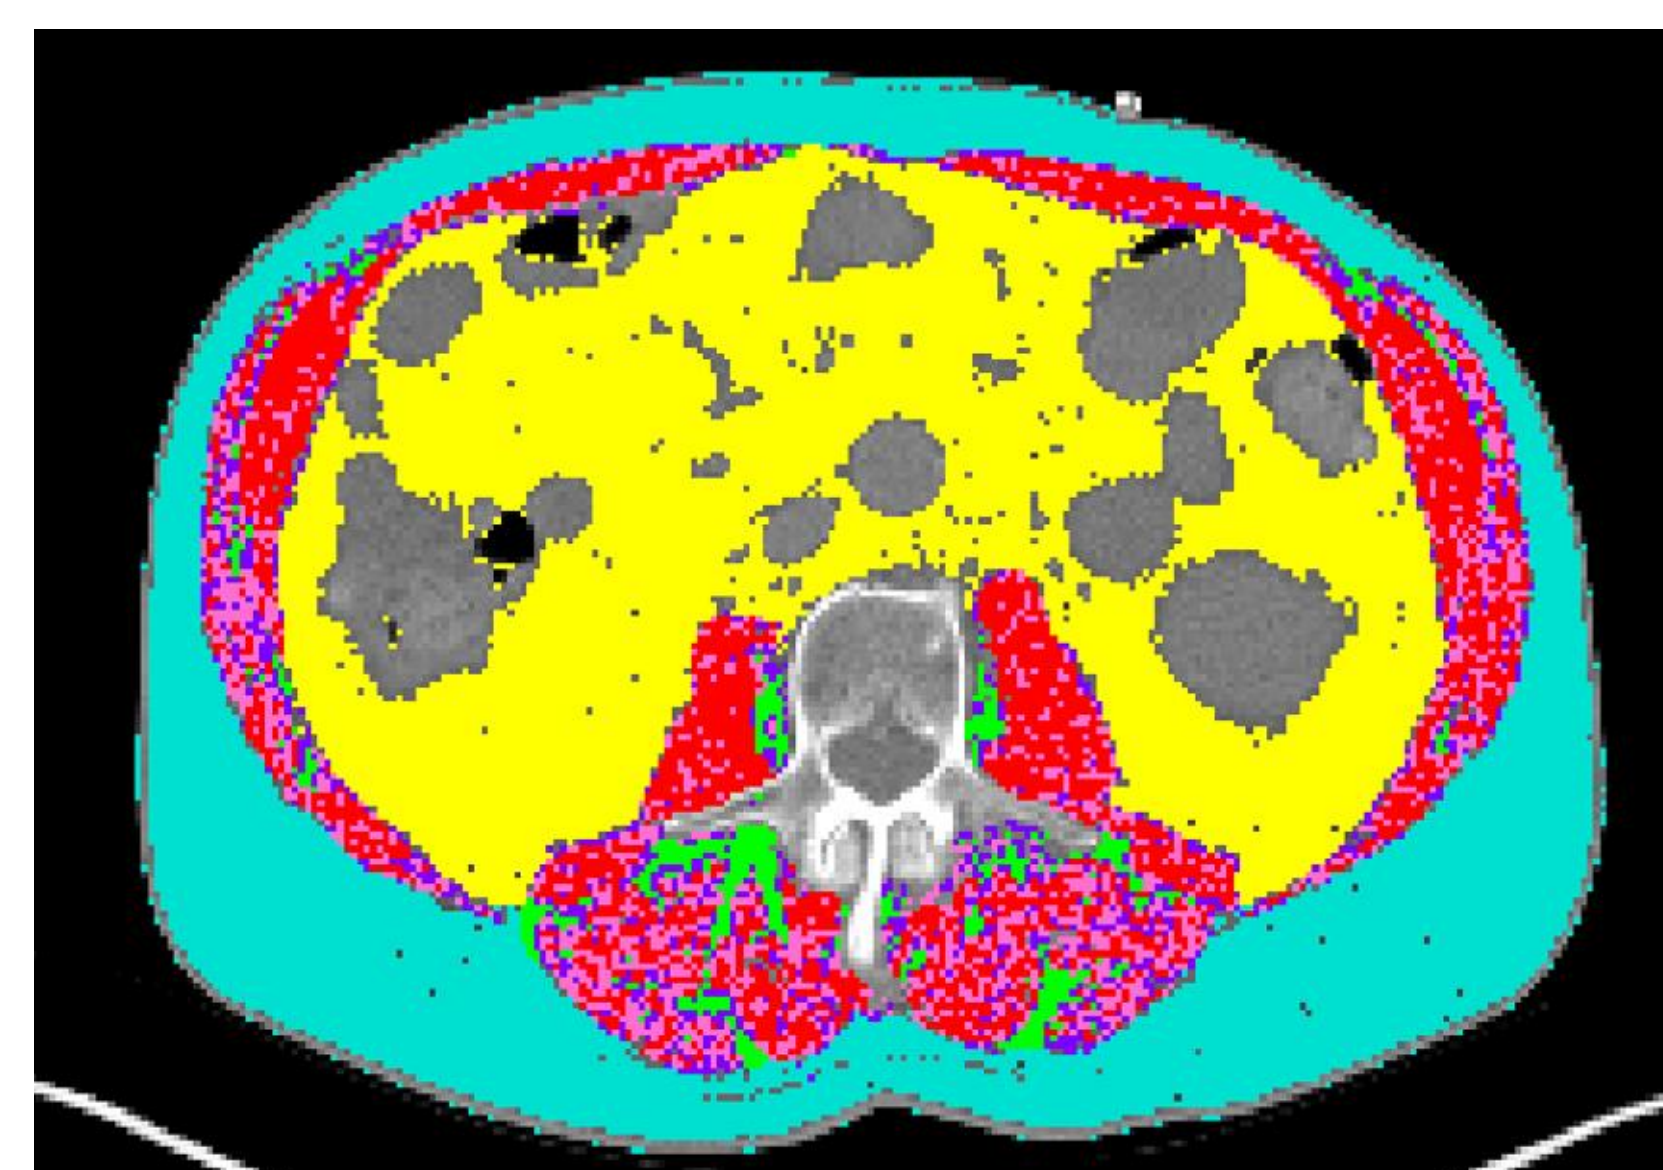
(left): CT scan of a patient at the L3 level using sliceOmatic™ to obtain the skeletal muscle index for analysis. Mean radiation attenuation (MRA) and inter/intra-muscular adipose deposition may be determined following tissue segmentation.
